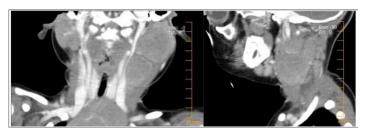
Case 2 is a 17-month-old female with hemoglobin-sc disease with 2 weeks of left sided neck swelling. CT of the soft tissue of the neck with intravenous contrast revealed 2 contiguous enlarged left cervical lymph nodes measuring up to 3 cm in diameter.
